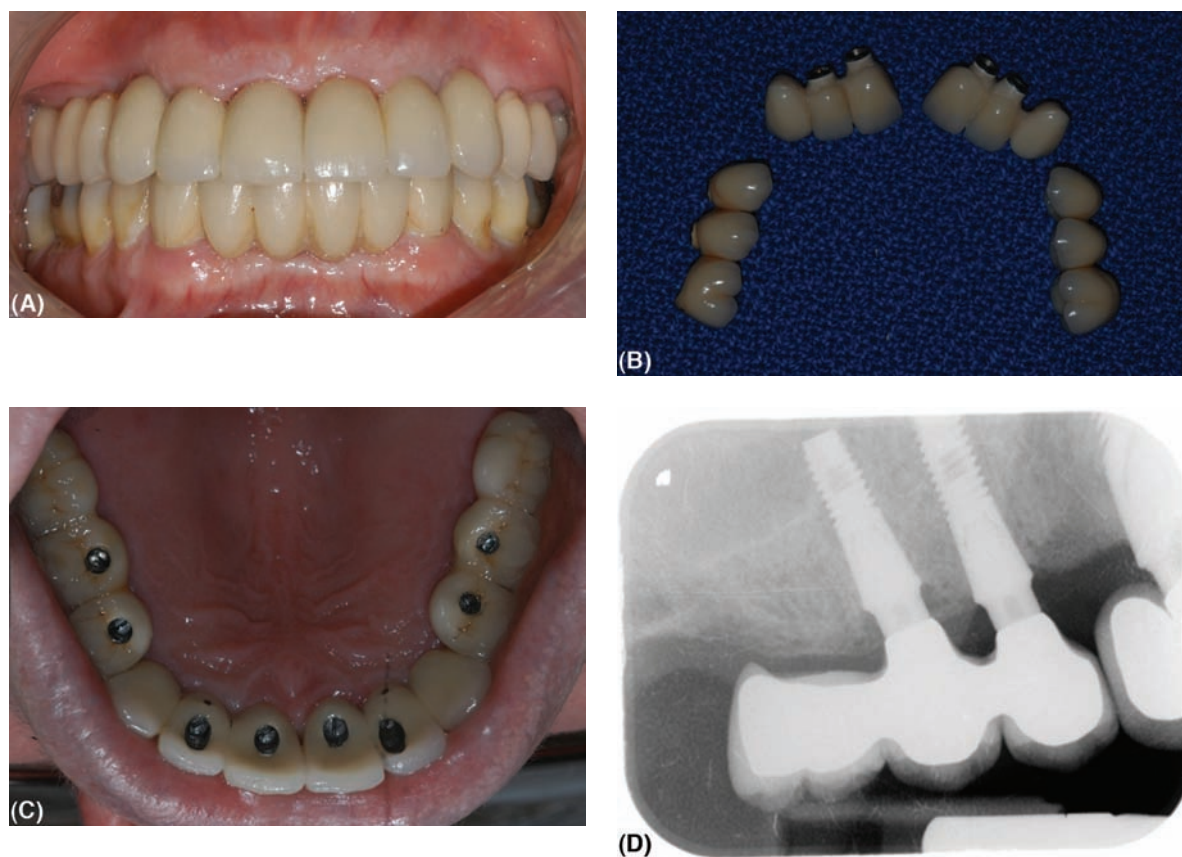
Full upper jaw screw-retained gold-ceramic bridges have been provided on eight implants: (A) The completed case. (B) Four separate bridges have been used, all linking two implants together with one pontic on each bridge. (C) From the occlusal aspect, the screw holes are in favorable positions. (D) One of the completion periapical radiographs showing implants in the premolar sites with one distal cantilever pontic.
